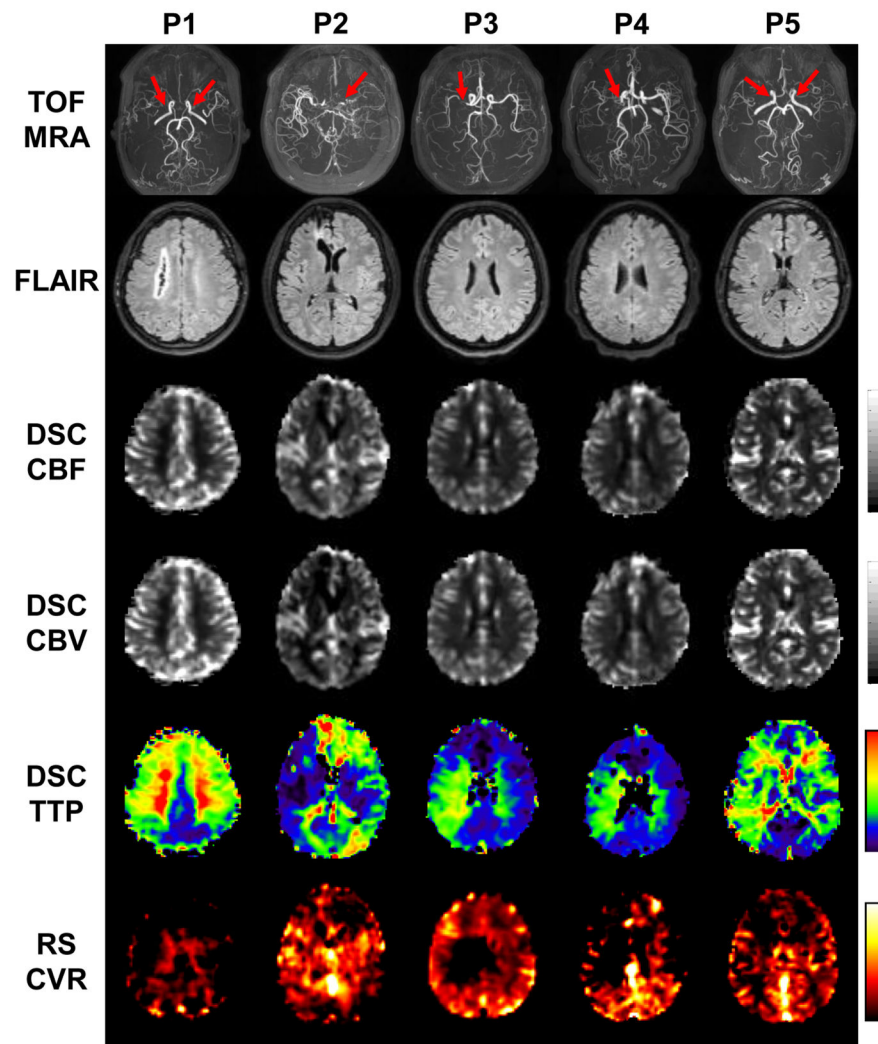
Imaging results from the five patients with Moyamoya diseases. Row 1: Time-of-flight (TOF) MR angiograms (MRA). Red arrows indicate the sites of arterial stenosis. Row 2: T2-FLAIR images. Row 3: DSC-CBF maps. Row 4: DSC-CBV maps. Row 5: DSC-TTP maps. Row 6: rs-CVR maps.
